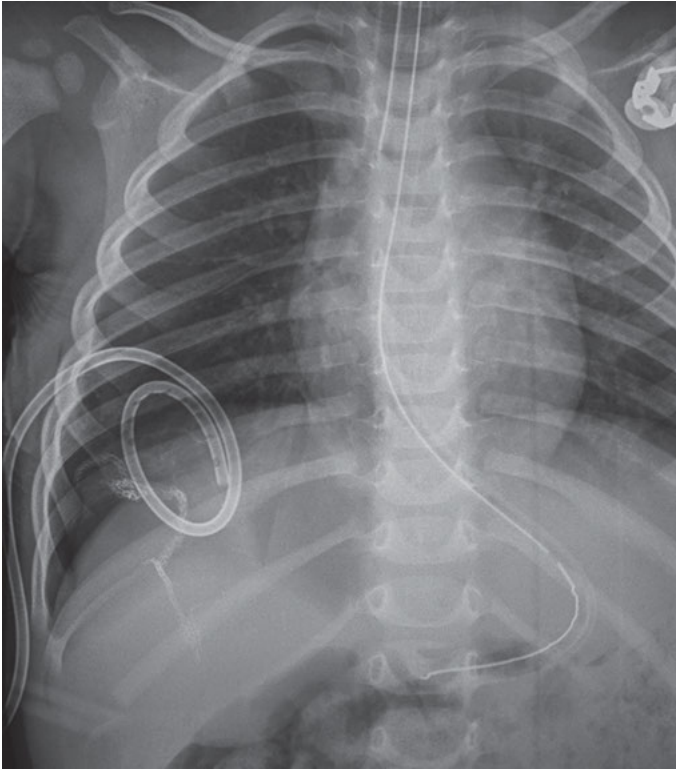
Thoracoscopic approach: resection/suturing of the excessive diaphragm with the use of an endostapler. Postoperative chest X-ray showing the stapler line.
